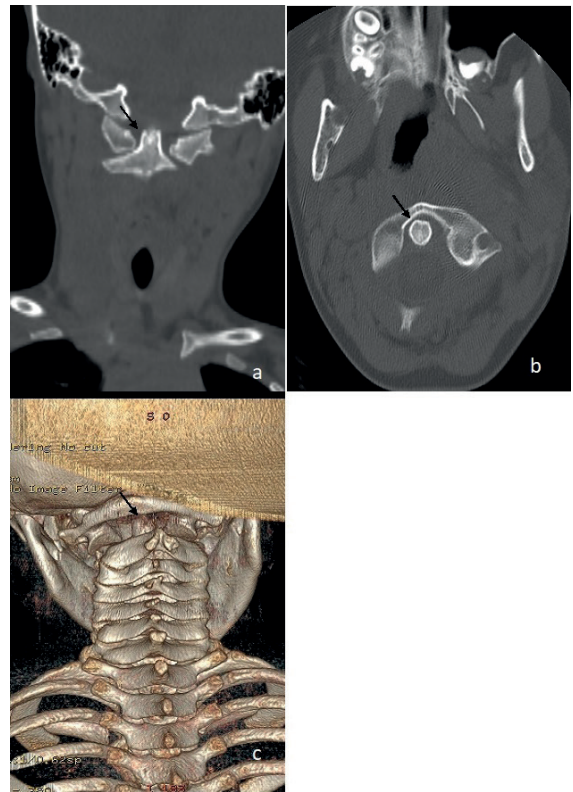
Narrowing and image matching with subluxation at right anterior of atlanto-axial joint range in coronal (a) axial (b) section and reformat 3D cervical (c) CT images (black arrows)
